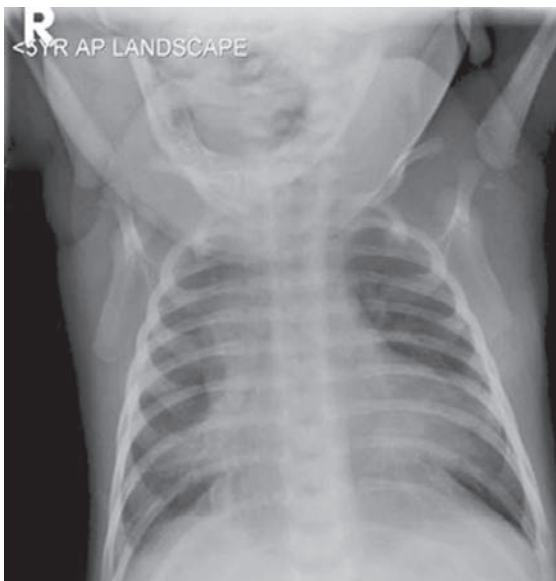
Viral pneumonias are mainly small and large airway disorders and radiological findings are due to partial and complete airway occlusion leading to atelectasis and hyperinflation. Chest radiograph in a month old baby with viral pneumonia showing hyperinflation and atelectasis of the lingula (seen as effacement of the left heart margin) and the middle lobe (seen as effacement of the right heart lobe)
